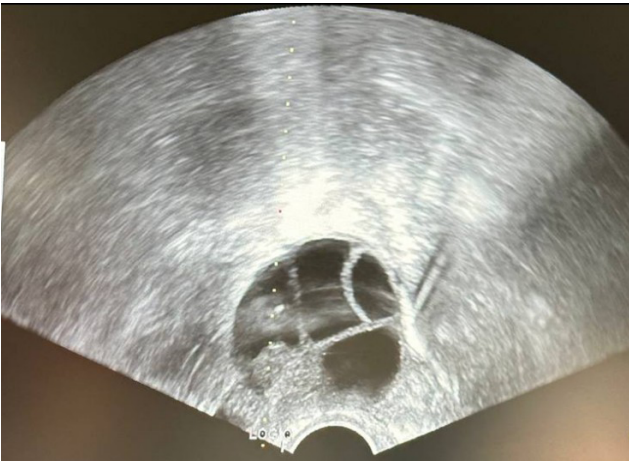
Ultrasound during transvaginal puncture (dashed line indicates ultrasound guidance).
